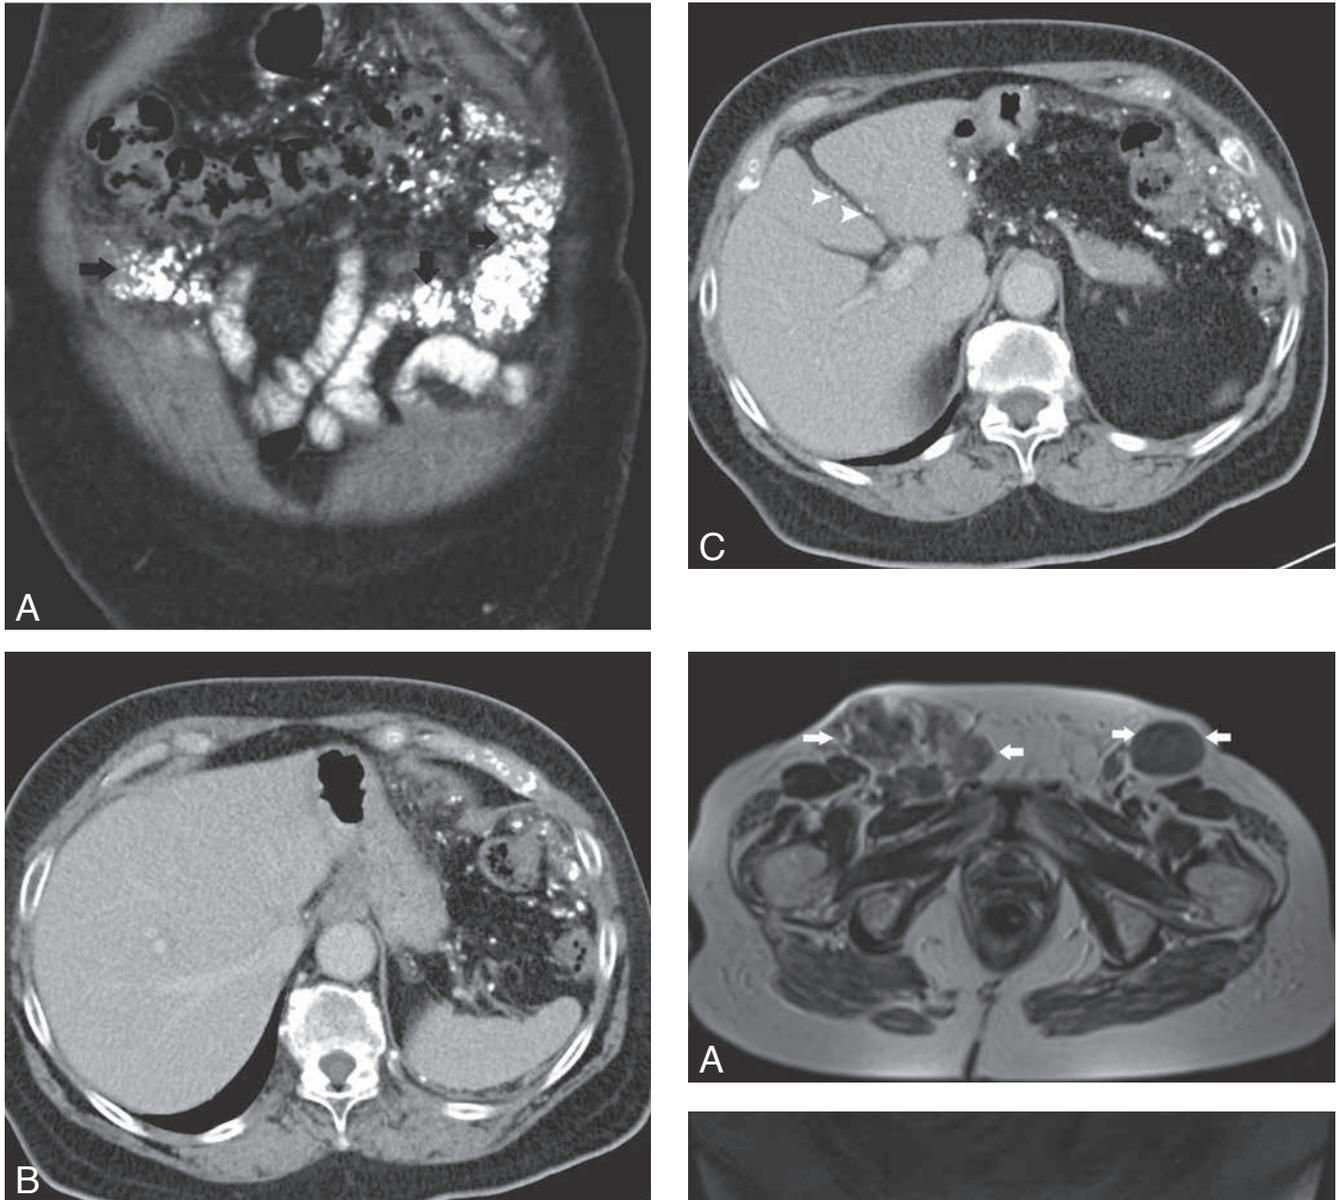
CT scan of the upper abdomen. Coronal reformatted image (A) showing thickening of the omentum which contains a mantle of speckled calcifications (black arrows). Axial image (B) revealing multiple nodular calcifications within the mesentery, the splenic hilum and the posterior surface of the spleen. Axial image at a slightly lower level (C). Note subtle calcification at the hepatic fissure (white arrowheads).
